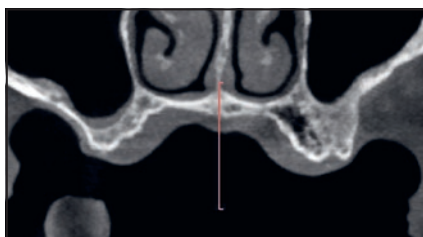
The soft tissue outline, revealed due to the contrast created by tissue separation, serves as numerous points of reference for CT and STL overlapping.
